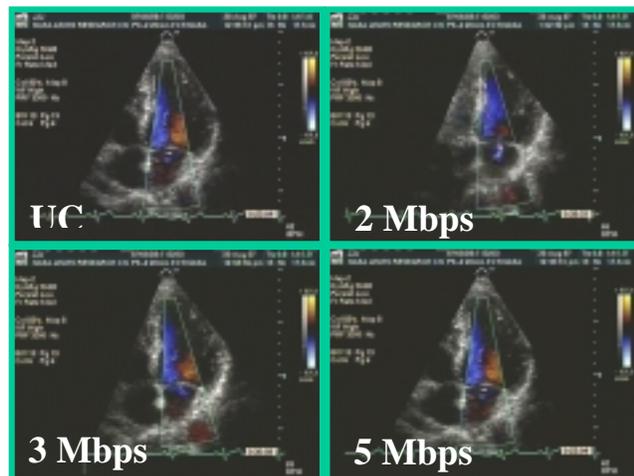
Echocardiographic images transmitted real-time using varying compression ratios. (UC: Uncompressed)
